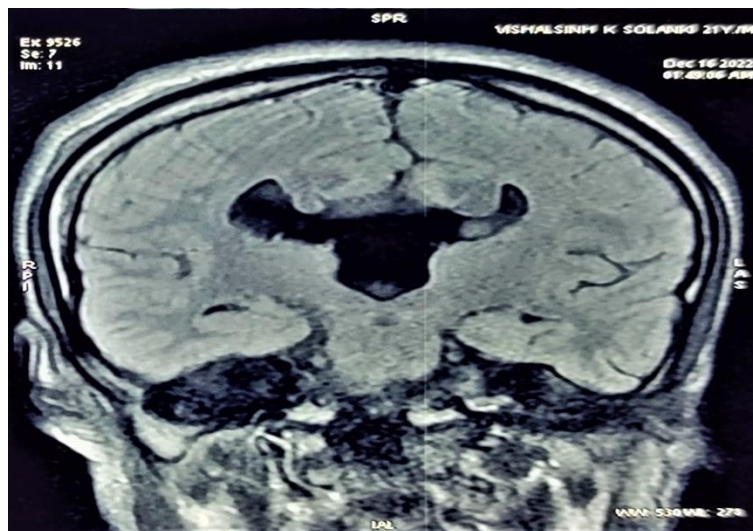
MRI Brain (FLAIR imaging) Coronal section showing absence of interventricular septum with "Viking helmet" appearance
